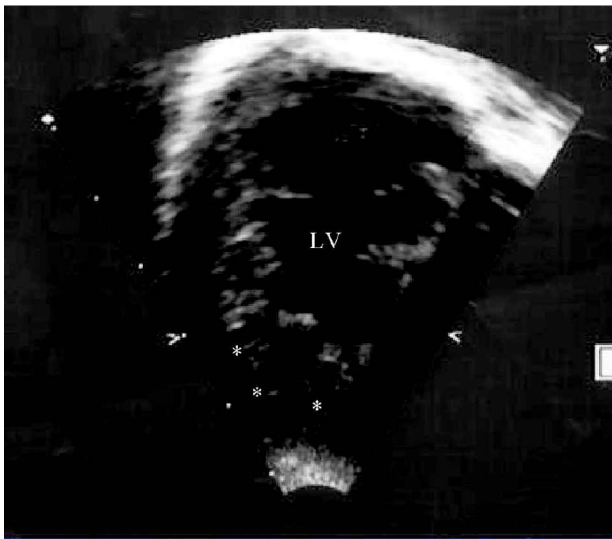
Echocardiography of the left ventricle in a child, showing deep trabecular recesses at the age of 6 months.
